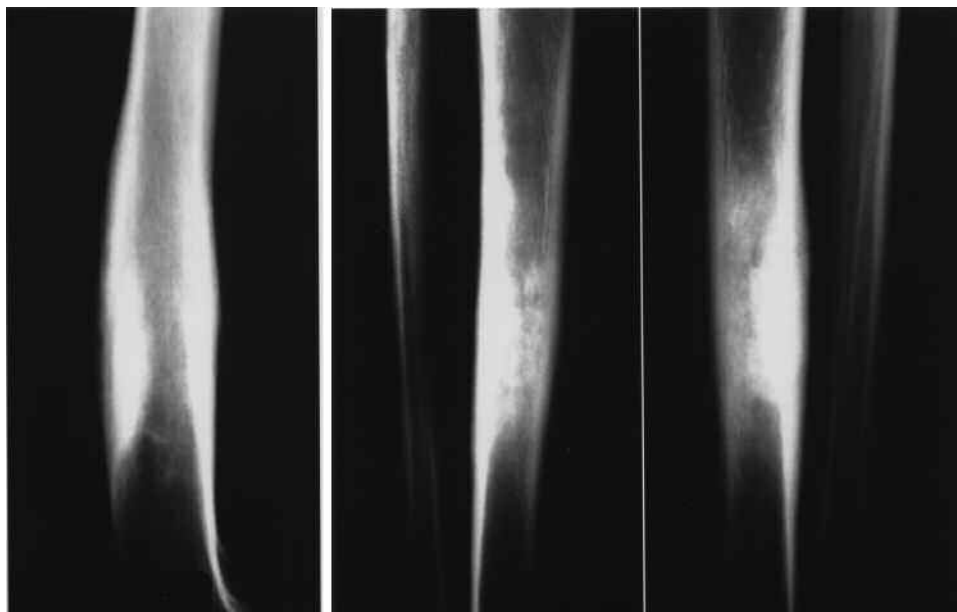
A and B Radiographs of both lower limbs, with cortical thickening at the diaphysis in the medium third of the tibias, medium third of the right and left femur, causing obliteration of the medullary cavity.
